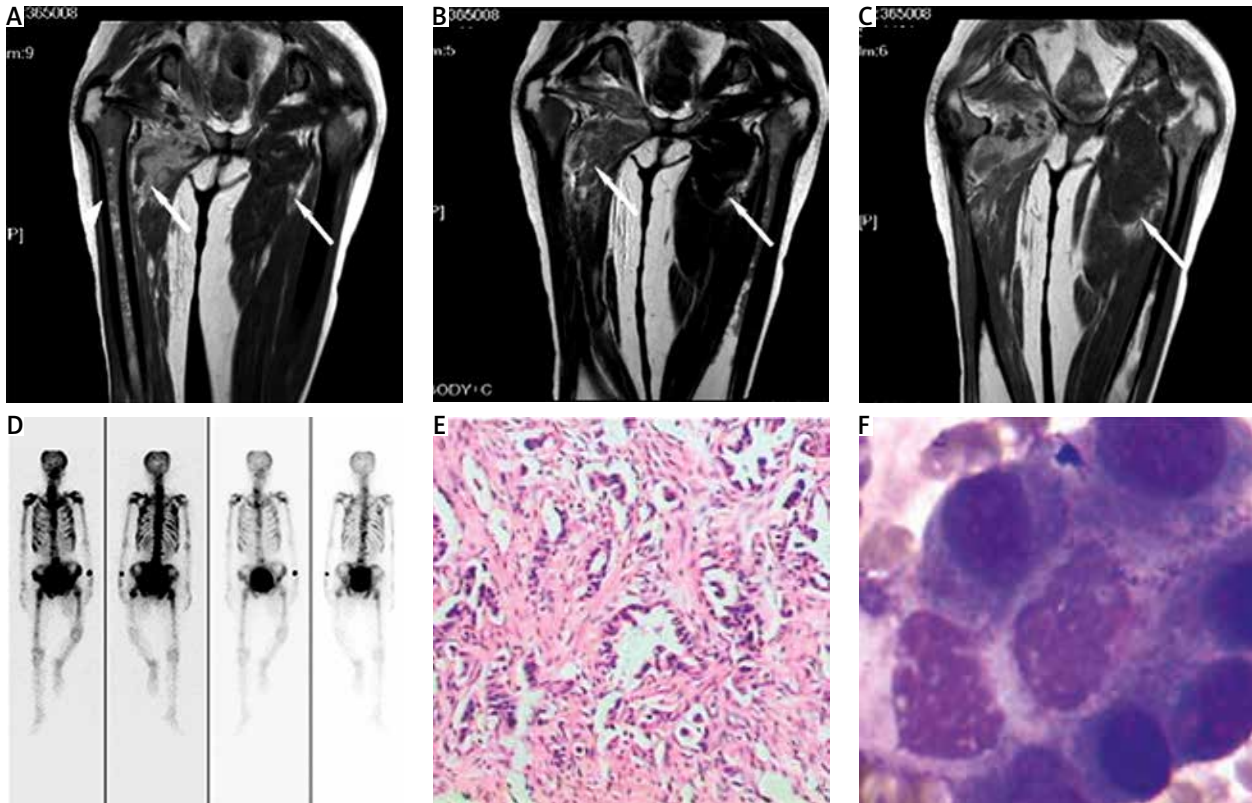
Type III SMM complicated by bone destruction in a 53-year-old woman with a primary cancer of unknown origin. Persistent pain in the adductor longus had continued for 9 months, and motion of the hip joint was limited. MRI showed a soft tissue mass without clear boundaries, slightly hyperintense signal intensity (A, arrow) with mixed signal intensity in the bone marrow (A, arrowhead) in T1WI, and heterogeneous hyperintense signal intensity in T2WI (B, arrow). Enhanced MRI showed moderate enhancement (C, arrow). Radioactive uptake can be seen in the right femur (D). Soft tissue puncture confirmed adenocarcinoma muscle metastasis (E) (200 \times magnification). Bone marrow biopsy confirmed bone marrow metastasis (F)
